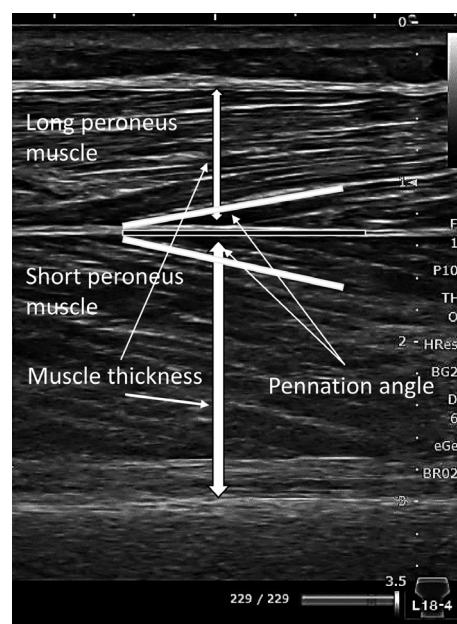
Pennation angle and muscle thickness of peroneus muscle group by ultrasound imaging.
